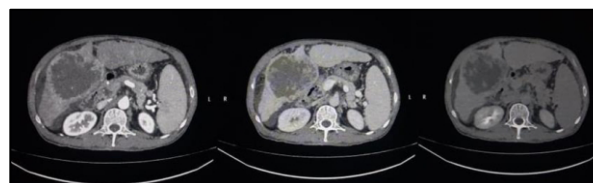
40-year-old Male Patient with Cirrhosis, LR M. An Arterial Phase CT Demonstrates 8.8x10.4x9.4 cm (APxTRxCC) Rim APHE Lesion Segment 5 and 6, Which Shows Peripheral Washout in both b Venous and c Delayed Phases (Arrows), No Other Feature. LR-M (Biopsy-Proven Cholangiocarcinoma)
